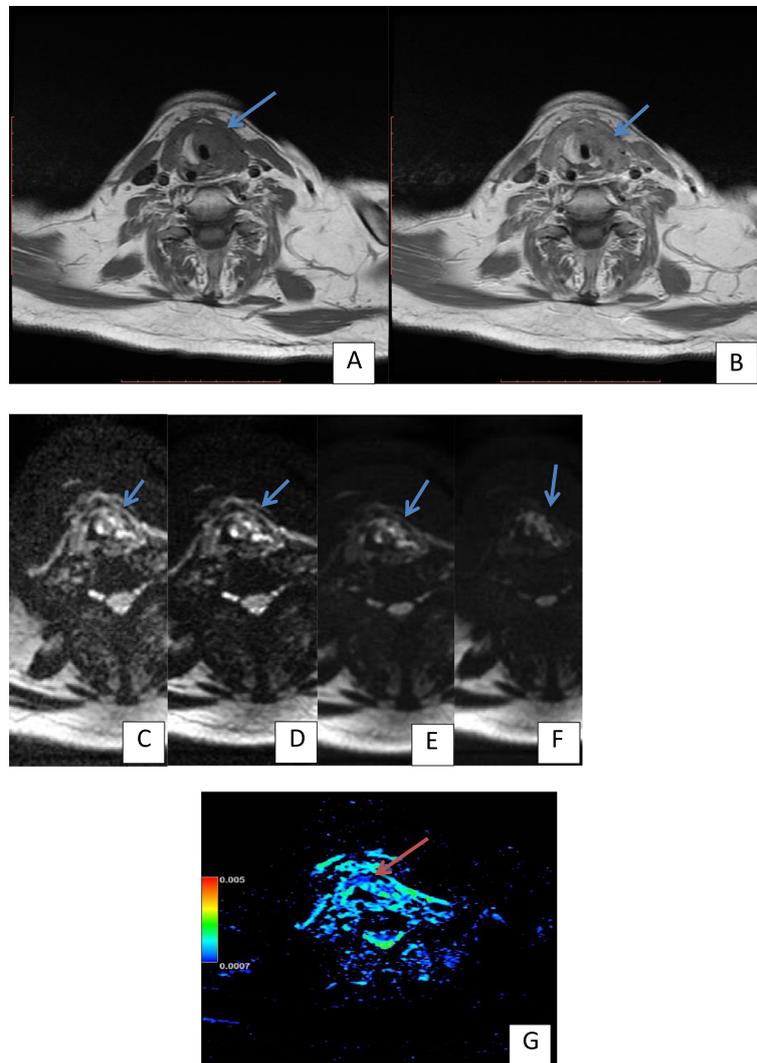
Sixty-four-year-old male patient with invasive laryngeal squamous cell carcinoma grade 2. a Axial T1. b Axial T1 + C. c–f Axial diffusion-weighted imaging with *b* values: 50, 400, 800, and 1000 respectively. g ADC map. The mass showed isointense signal in T1 with small areas of necrosis, homogenous enhancement of solid tissue after IV contrast. It elicited high signal in DWI, in both low and high *b* values with corresponding low signal intensity in ADC map (restricted diffusion), ADC value = $0.607 \times 10^{-3} \text{ s/mm}^2$ (low)
